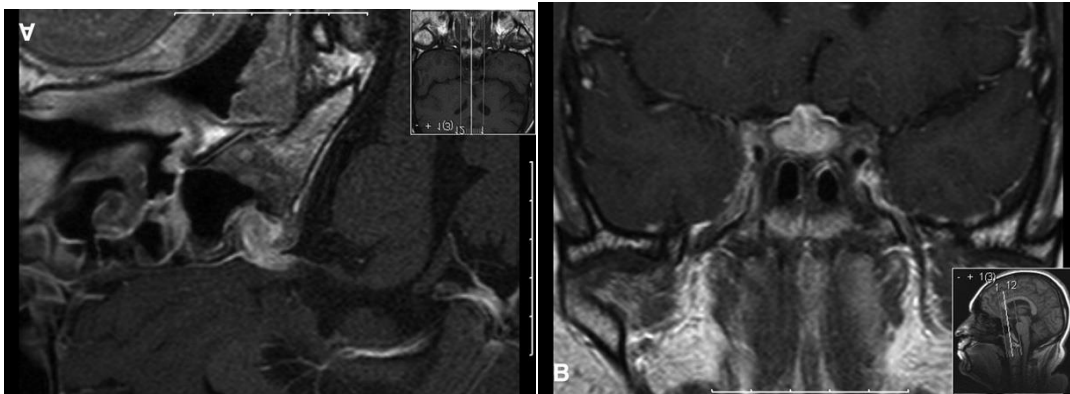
T1 weighted sagittal& coronal MRI showing enhancement of the hypothalamus and pituitary stalk in Sarcoidosis. (Frohman et al., 2003); (Koszman et al., 2008)
